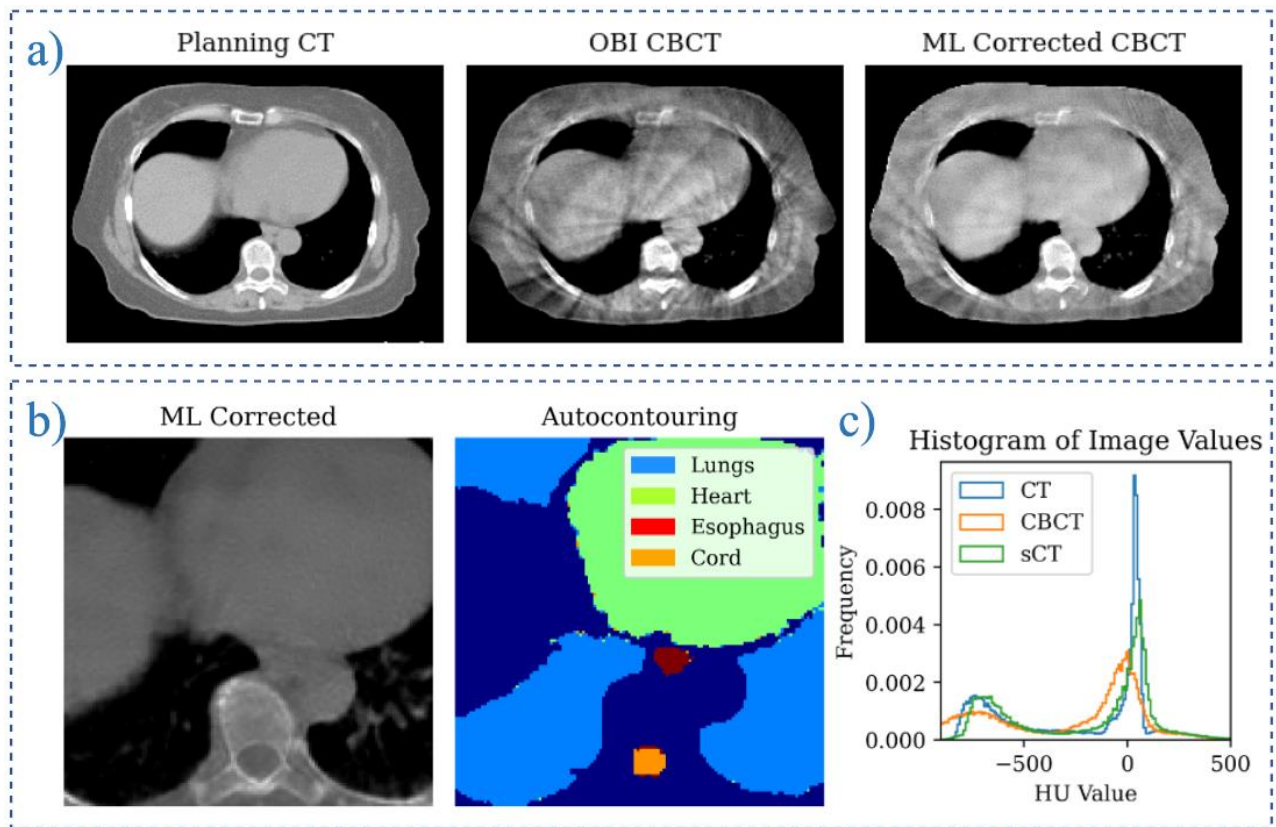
a) A planning CT is compared to a registered CBCT and the stitched, full-volume sCT. b) The auto-contouring capability of the model is demonstrated. c) The conversion from CBCT HU values to sCT HU values is seen.
